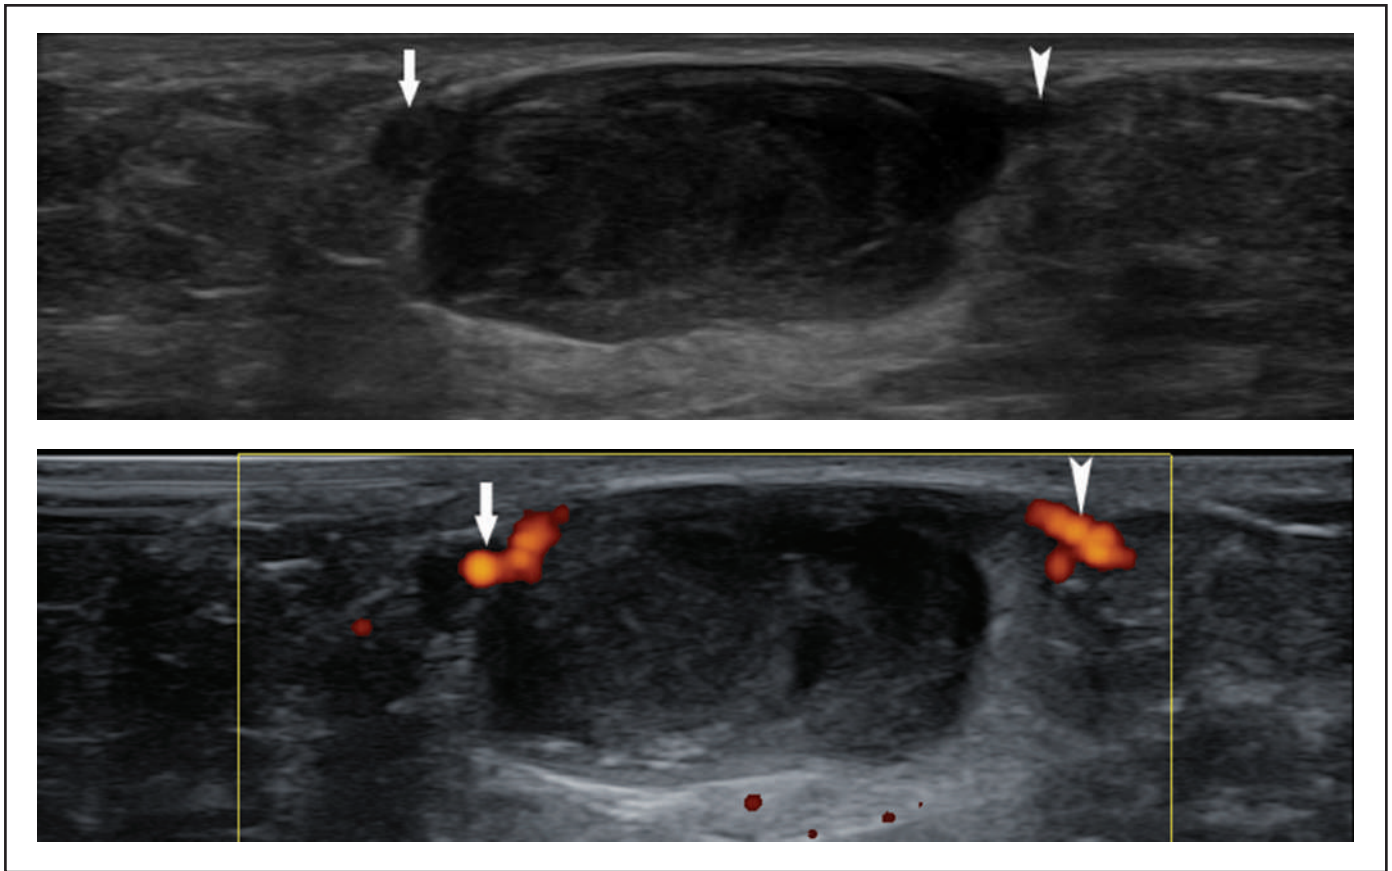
The hypoechoic structure and its vessel connections. (A) The hypoechoic structure connects with the cranial vessel (arrow) and the caudal vessel (arrow head). (B) Power Doppler demonstrates blood flow in the connections.
